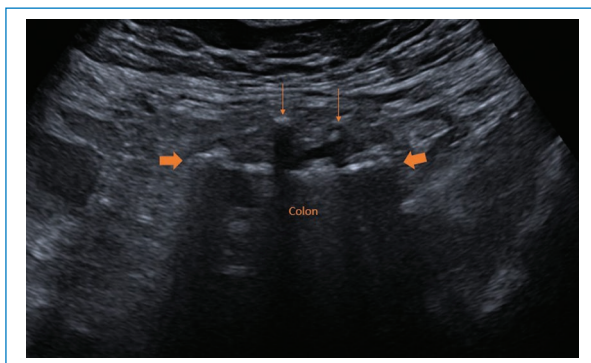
Ultrasound showing two diverticula in the descending colon (thin arrows), herniations of the mucosal and submucosal layer through the wall of the colon (hyperechoic, thick arrows).
